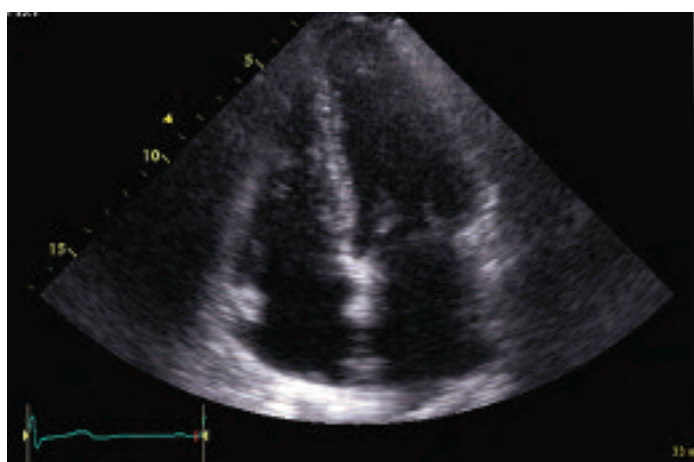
Four-chamber apical view on transthoracic echocardiography. Normal right and left ventricular chamber size. Normal right atrium size. Borderline normal-mild left atrium enlargement.
